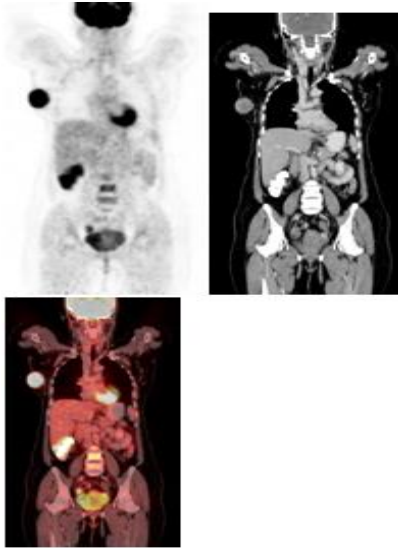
Maximum intensity projection (MIP) image of FDG PET showing a stage IV invasive ductal carcinoma of right breast tumor stage T4 with nodal and liver metastasis. The pSUVmax of the primary tumor was 20.4. It was triple negative breast cancer.
